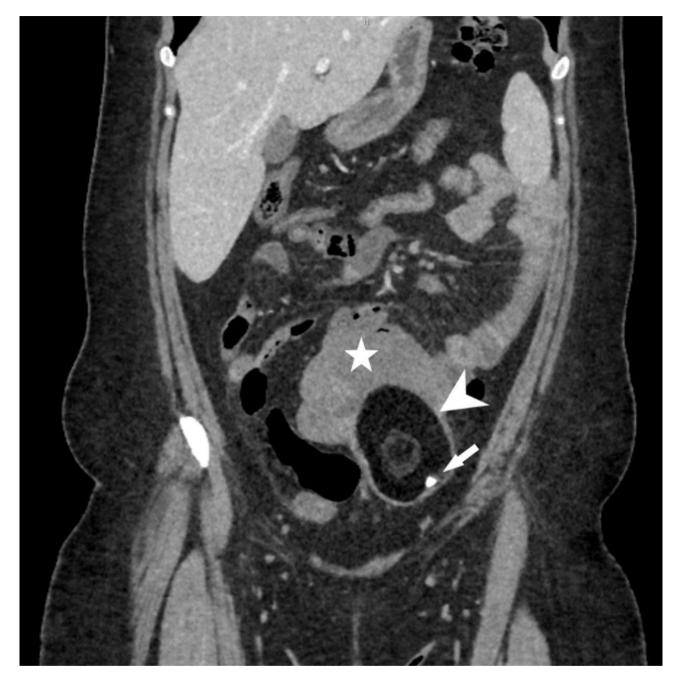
The coronal plane of the contrast-enhanced abdominopelvic CT (0.625 mm slice thickness) scan reveals a complex lesion located in the abdominal cavity. An oval-shaped, fat-rich mature cystic teratoma is identifiable, marked with a white triangle. Notably, the teratoma contains calcifications, highlighted by a white arrow. Positioned superiorly, a component suggestive of malignant transformation is visible, indicated by a white star
